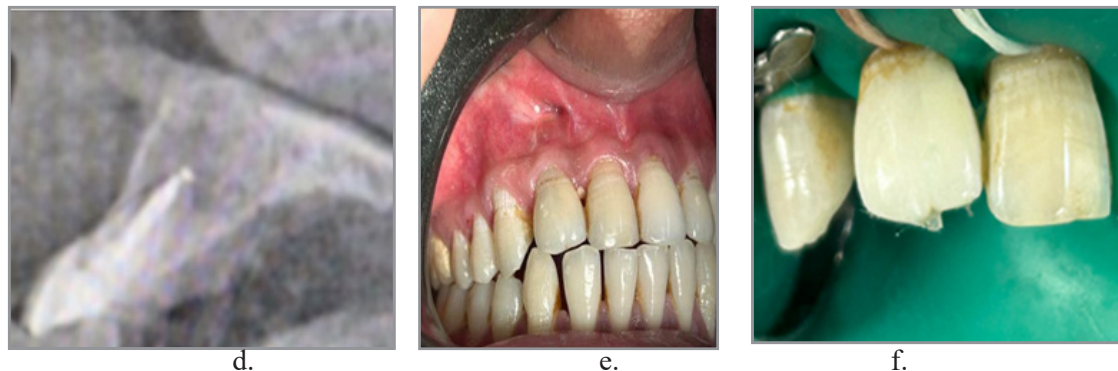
a) apical barrier of MTA, followed by thermoplasticized gutta-percha obturation b) 12 month follow up c&d) CBCT scan after 6 month showing healing e) Postoperative photograph showing healing with scar formation at the decompression site f) restored tooth
